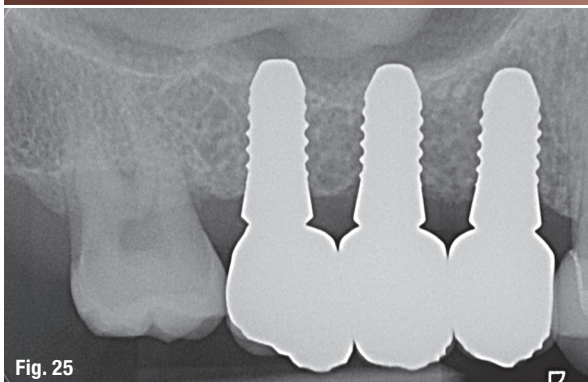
Lateral view of the inserted implant crowns. Fig. 25: Radiographic control after insertion of the final prosthetics. The regenerated intraosseous defect in region #18 mesial has to be noted.
